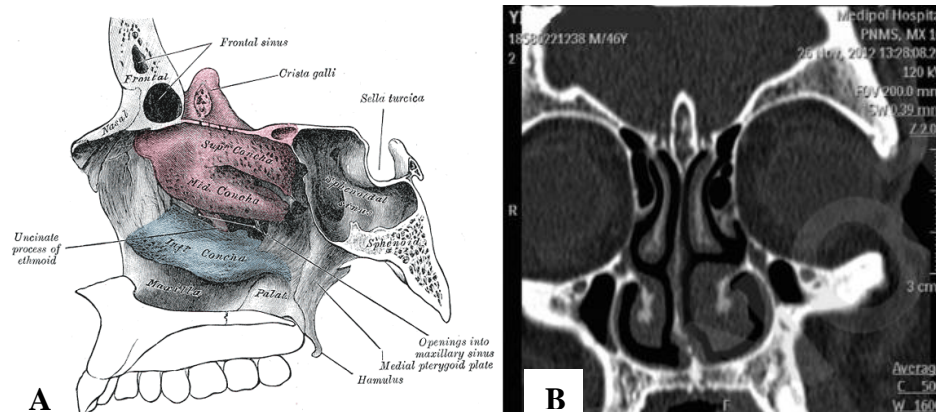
Superior, middle and inferior nasal turbinates (A) (From Henry Gray, 1918). Deviated nasal septum and enlarged left inferior turbinate on CT imaging (B).
